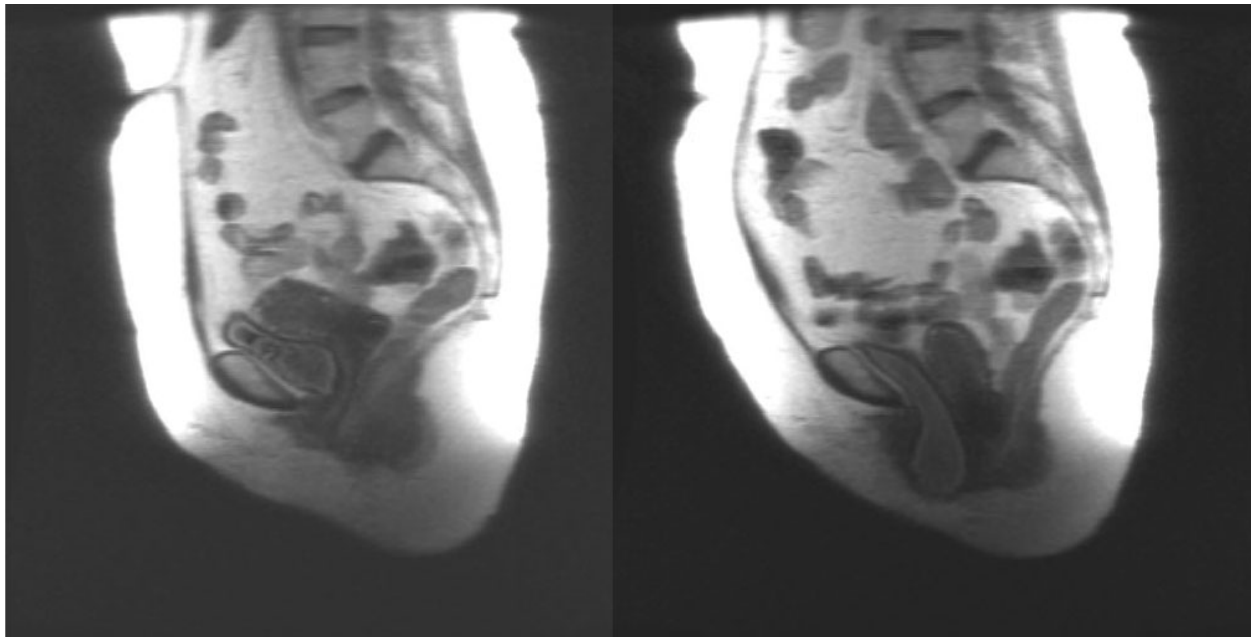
The rest and strain image taken from a mid-sagittal dynamic MRI sequence revealing cystocele and uterine descent using SSFSE sequence.
